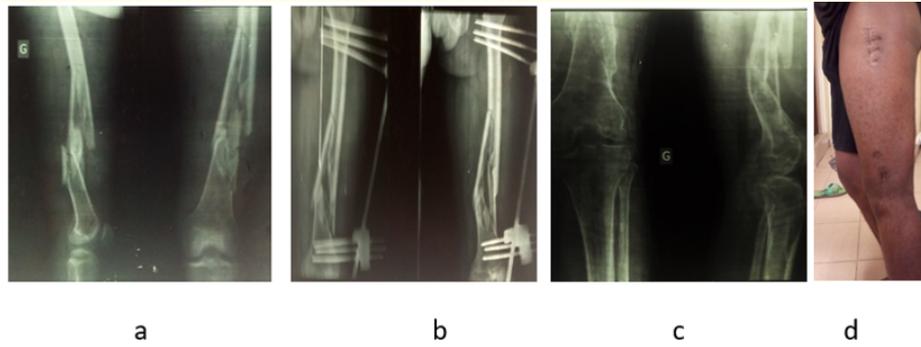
3a open ballistic diaphysometaphyseal comminuted fracture of the left femur (type C3). 3b: osteosynthesis of the femur by FESSA. 3c: AP/profile x-ray showing a malignant callus (2 years of evolution). 3d: clinical evolution after 2 years.
